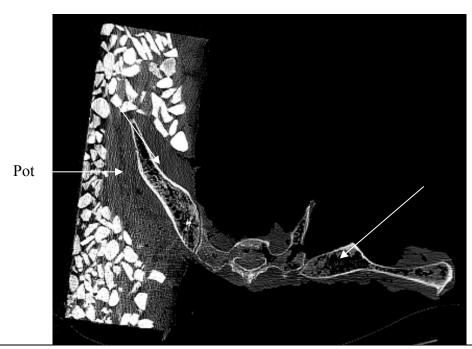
Axial CT scan of Test 5 demonstrating a disrupted left sacroiliac joint (arrow).
